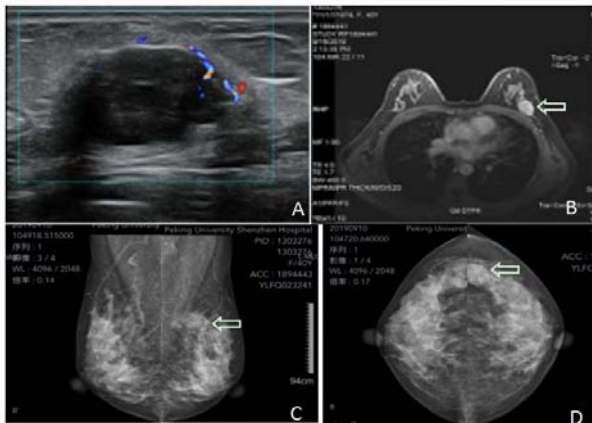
Preoperative imaging scans of the breast lesion before first surgery. Panel A: Ultrasound of breast showed a hypo echoic mass, 28 mm x 27 mm x 16 mm, 5 cm from nipple-areolar complex and 6 mm from the above skin. Panel B: Magnetic Resonance Imaging (MRI) of the breast showed an irregular shaped mass with the size of 23 mm x 17 mm in the upper outer quadrant of left breast. Panel C: External oblique position and Panel D: coronal position of breast mammography showed a slightly high dense irregular mass, 23 mm x 21 mm, in the upper outer quadrant of left breast with no abnormal lymph nodes in ipsilateral axilla.
